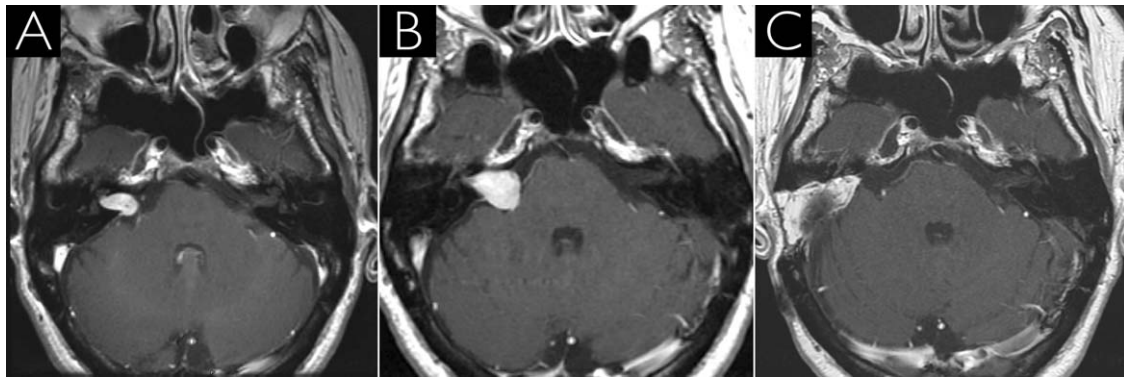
Serial axial T1-weighted MRI with gadolinium (A) demonstrating a right-sided vestibular schwannoma with 0.5 cm of cisternal extension that was treated with primary stereotactic radiosurgery. (B) Following radiation, the tumor demonstrated progressive growth to a size of 1.2 cm over the course of 3.4 years. (C) The patient subsequently underwent translabrynthine craniotomy with gross total resection and has no evidence of residual progressive disease with over 2 years of follow-up.
